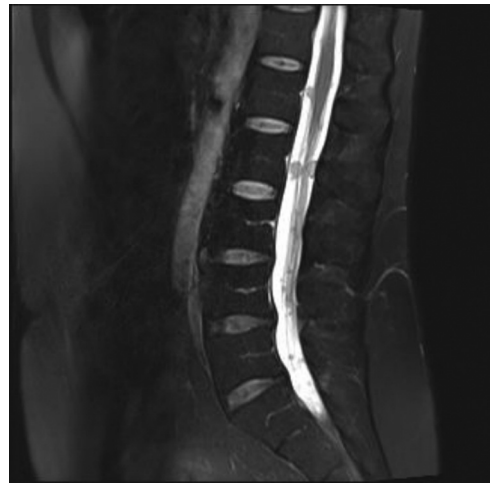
Sagittal post contrast MRI T2 of the lumbar and lumbosacral spine showing dural lesion at the level of L1 until conus medullaris.
